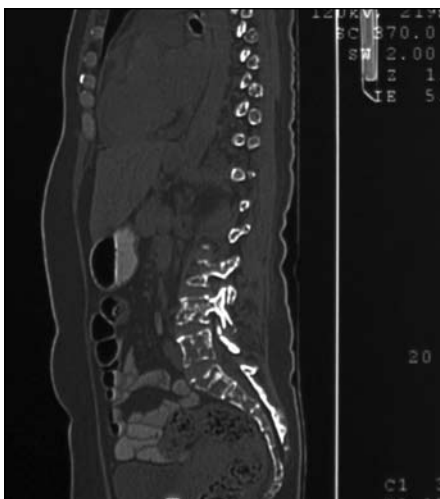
CT scan in sagittal section revealing widespread destructive lytic metastases within the vertebrae
